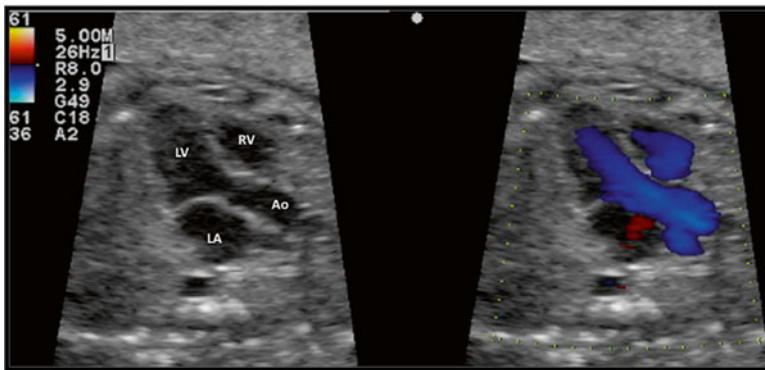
Fetal echocardiographic view of normal left ventricular outflow tract with 2D-US (*left*) and color Doppler (*right*). Note the ascending aorta arising from the left ventricle. *Ao* aorta, *LA* left atrium, *LV* left ventricle, *RV* right ventricle
